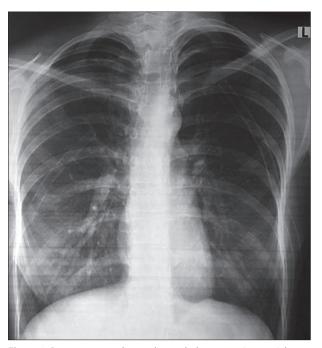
Chest radiograph on admission demonstrating bilateral pneumothoraces
